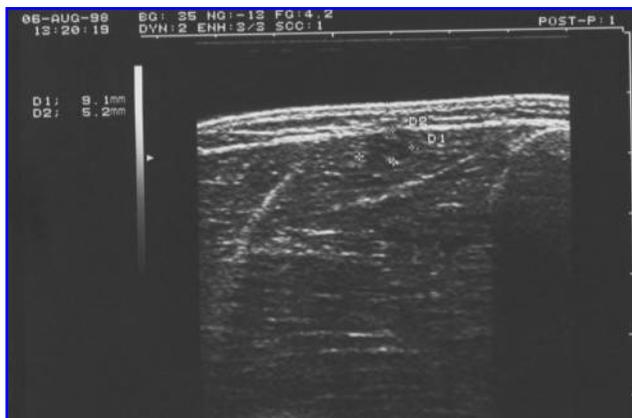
Sonography findings immediately after the injury occurred.
